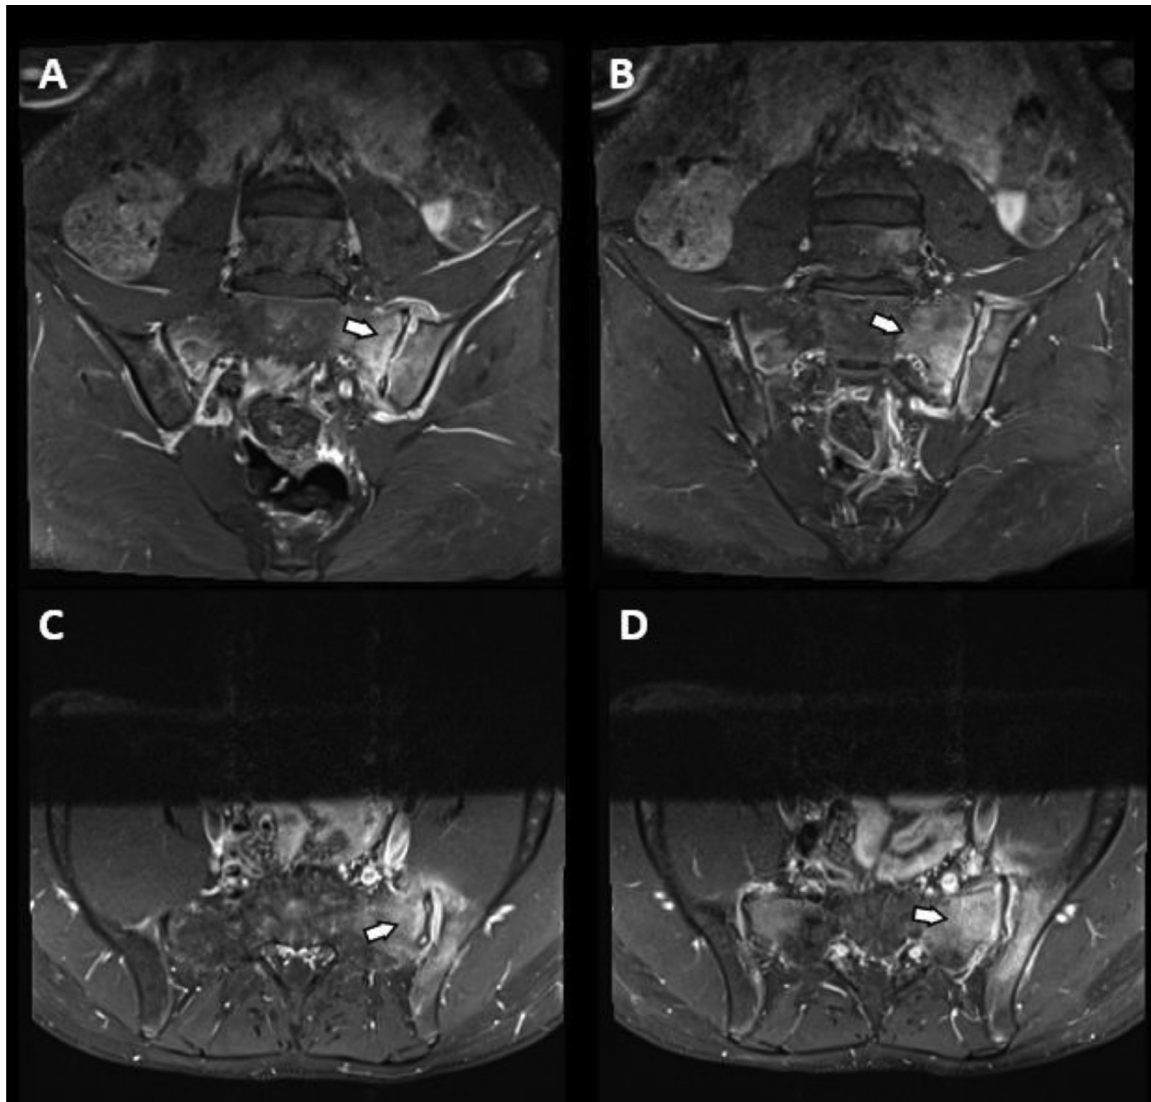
A, B - Coronal T1 sacroiliac joint magnetic resonance imaging (MRI) post gadolinium. C, D – Axial T1 sacroiliac joint MRI post gadolinium. Asymmetric bone marrow and para-articular enhancement, more extensive at left sacroiliac joint.
